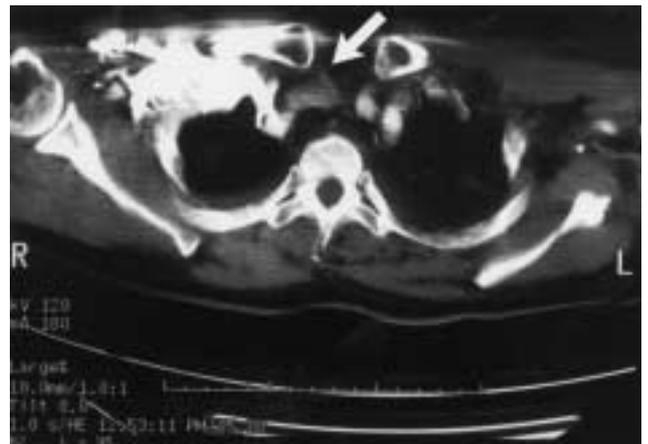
Preoperative CT scan demonstrating aortic dissection.
